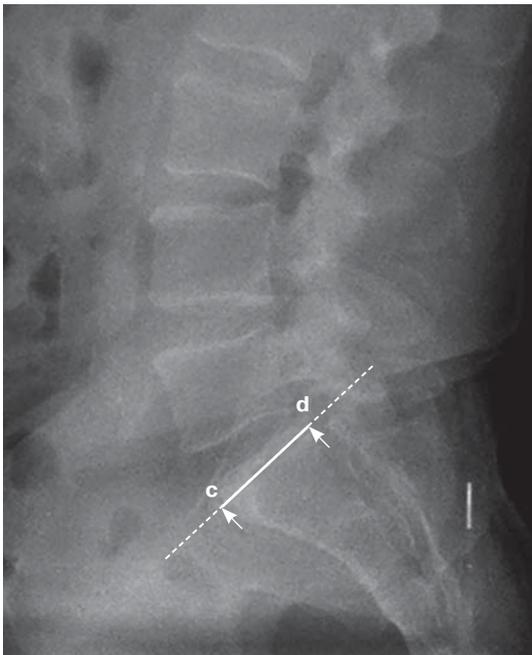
X-ray image of the lumbosacral spine in sagittal projection. c is the front point of the sacrum base contour; d is the back point of the sacrum base contour; cd is the absolute value of the segment “sacrum”.
